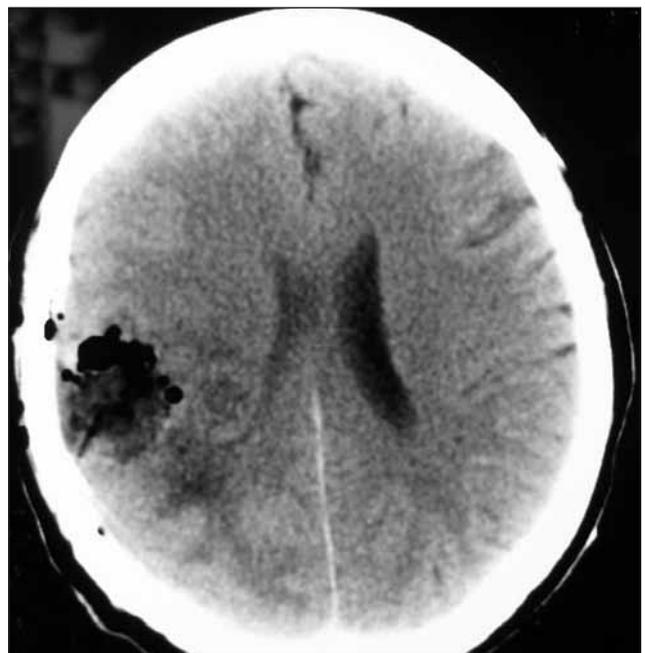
Postoperative CT image reveals successful evacuation of the lesion.
